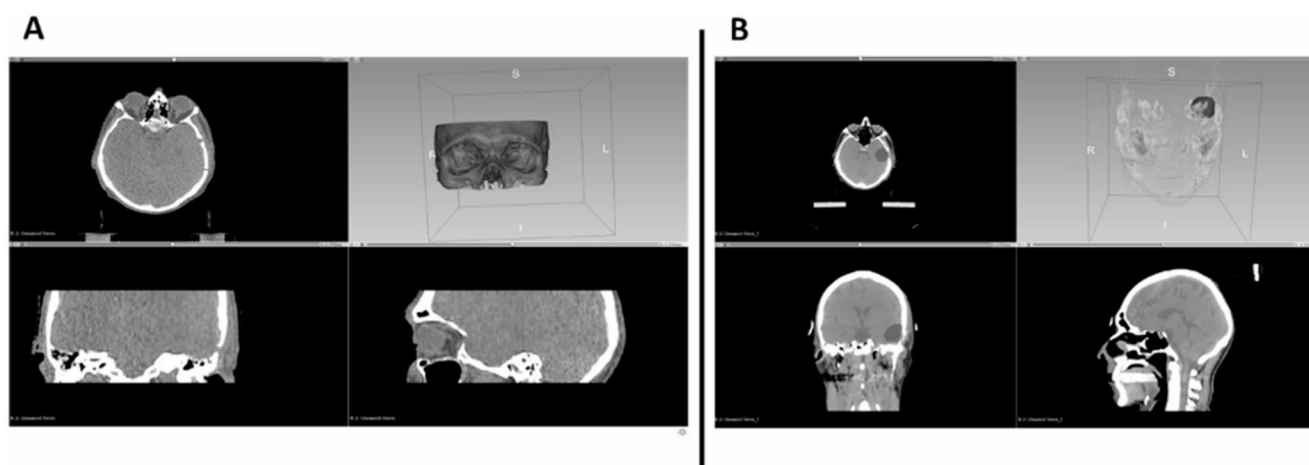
Problems related to quantitative evaluation of daily (A) radiotherapy effectiveness due to the problematic nature of tumour (marked in B) volume detection from initial (B) kV-CBCT images
